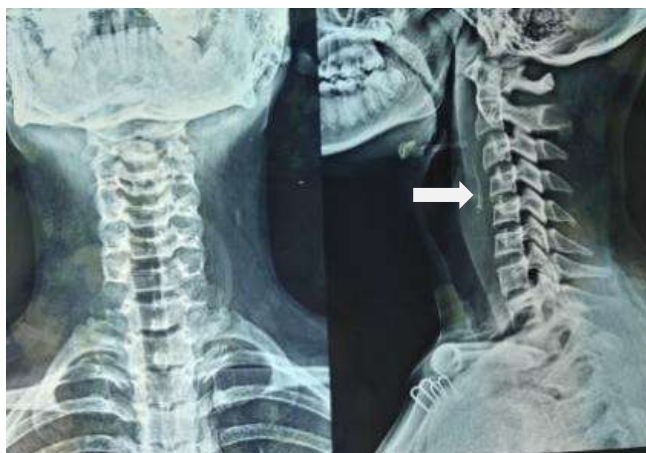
Xray imaging showing foreign body in prevertebral space (White arrow)
